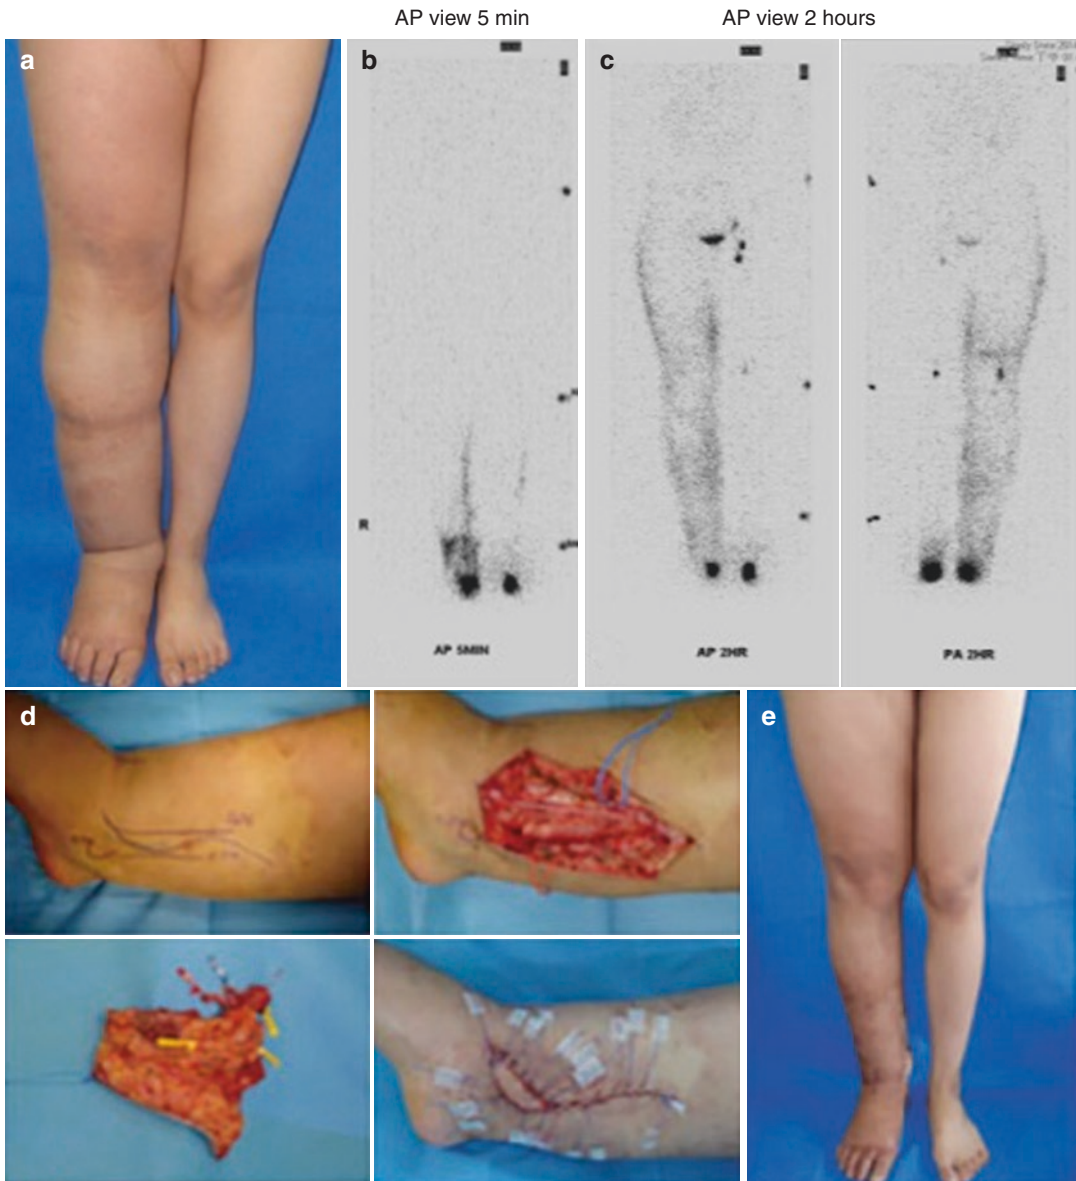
A 19-year-old female with right lower extremity lymphedema since birth and a history of Klippel–Trenaunay Syndrome. Her preoperative circumferential difference was 48.8% above-knee and 42.9% below-knee (a). Lymphoscintigraphy showed partial obstruction pattern, Taiwan lymphoscintigraphy stage P-3 with absent ilioinguinal lymph nodes, uptake of popliteal lymph nodes, and entire dermal backflow in the right lower limb (b, c). She underwent vascularized submental lymph node flap transferred to the right ankle (d). Anatomical landmarks for recipient site preparation (upper left d). Posterior tibial
